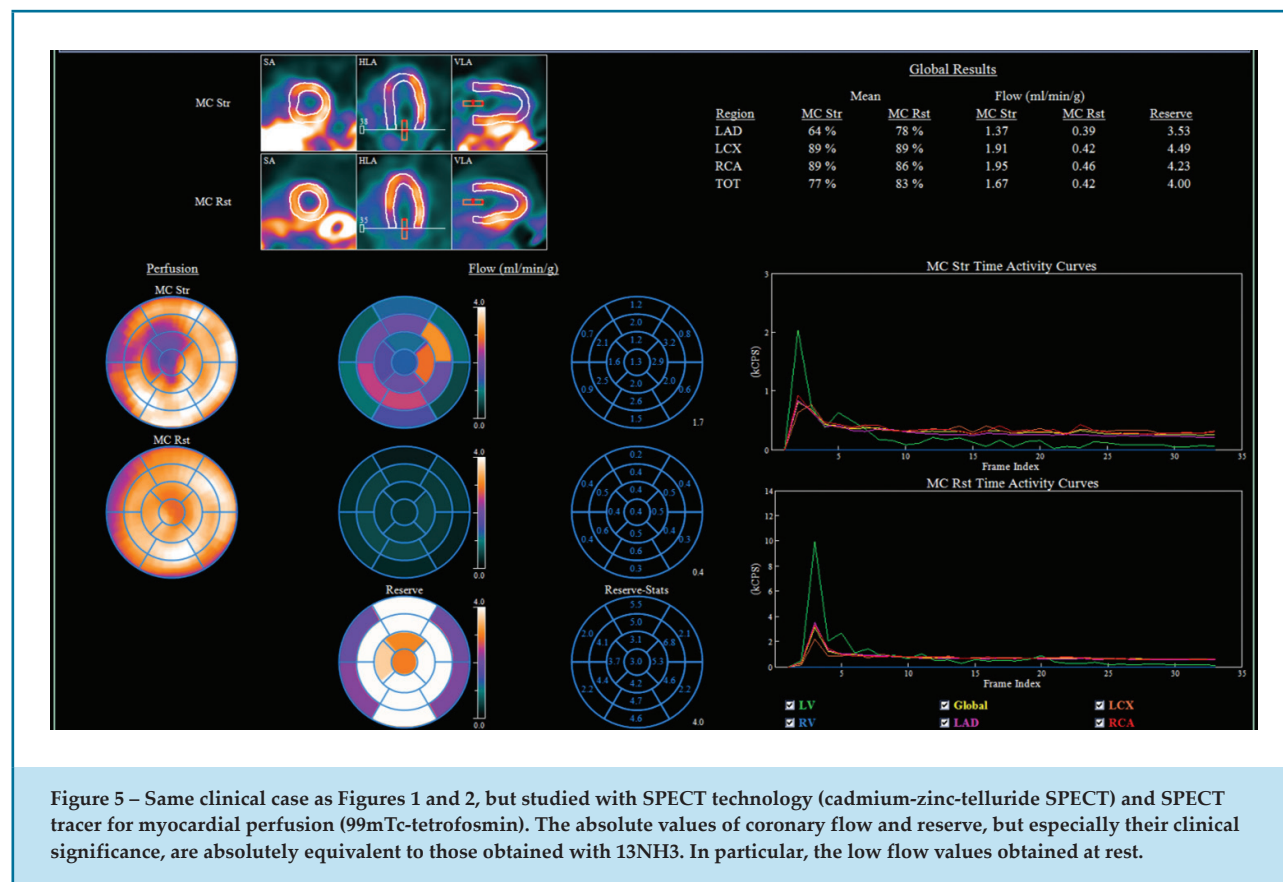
Same clinical case as Figures 1 and 2, but studied with SPECT technology (cadmium-zinc-telluride SPECT) and SPECT tracer for myocardial perfusion (^{99m}Tc -tetrofosmin). The absolute values of coronary flow and reserve, but especially their clinical significance, are absolutely equivalent to those obtained with $^{13}\text{NH}_3$. In particular, the low flow values obtained at rest.
